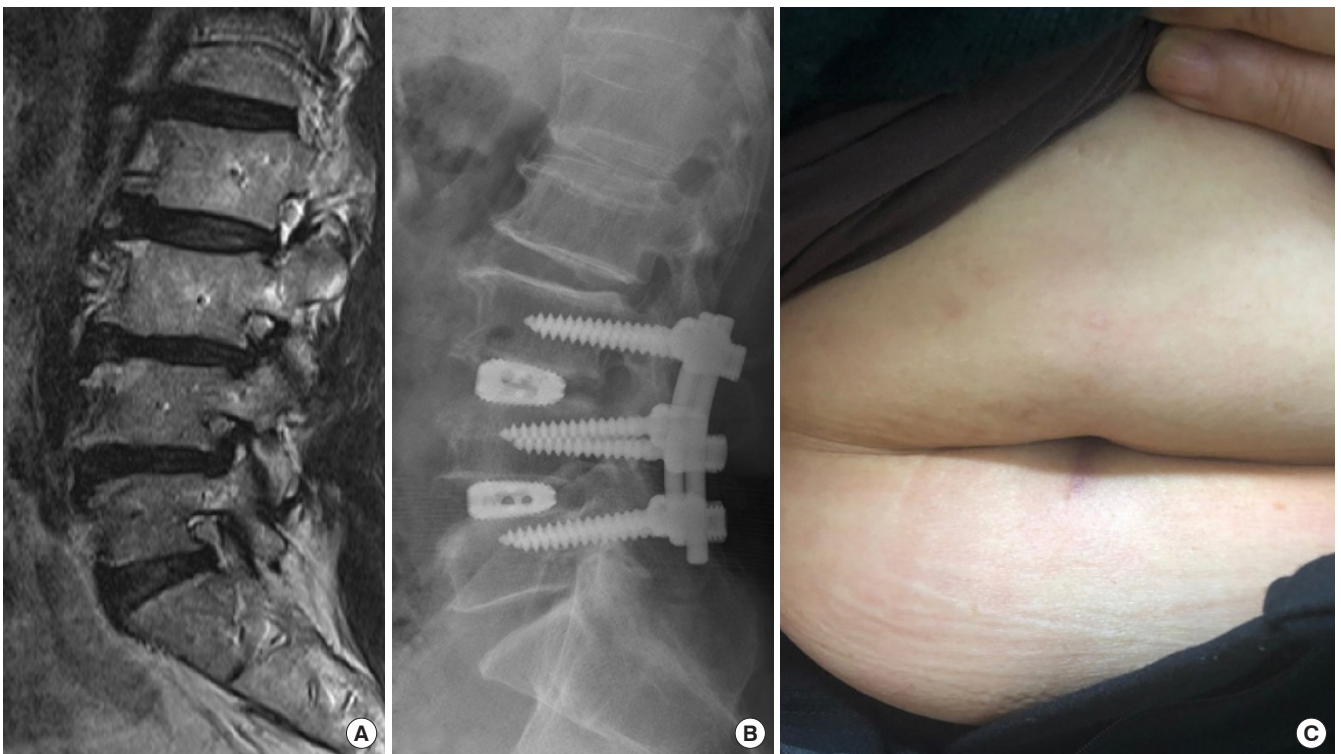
(Case 2) Preoperative magnetic resonance imaging scan (A), postoperative x-ray (B), and photograph of the abdominal scar after 6 months postoperatively (C).
